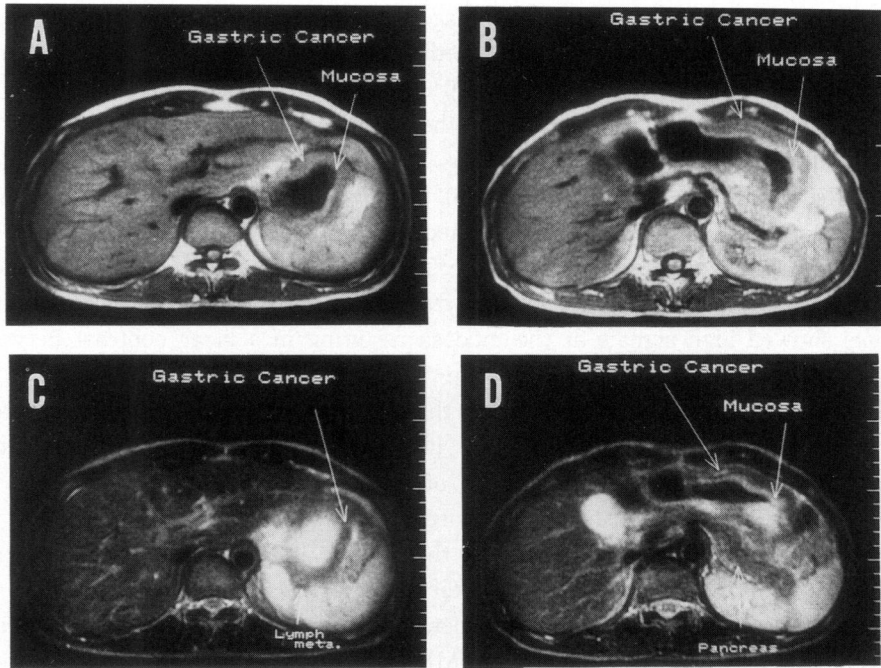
MRI of scirrhus cancer of the stomach (case 5).
